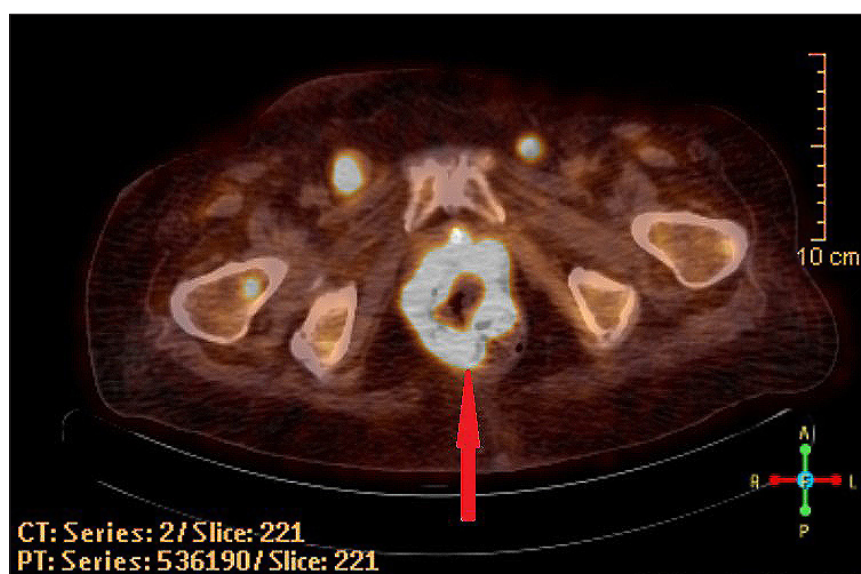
Positron emission tomography-computed tomography (PET-CT) of Case 1. The arrow indicates the rectal mass consistent with poorly differentiated neuroendocrine carcinoma. Additional findings include extensive lymphadenopathy and skeletal metastases.
